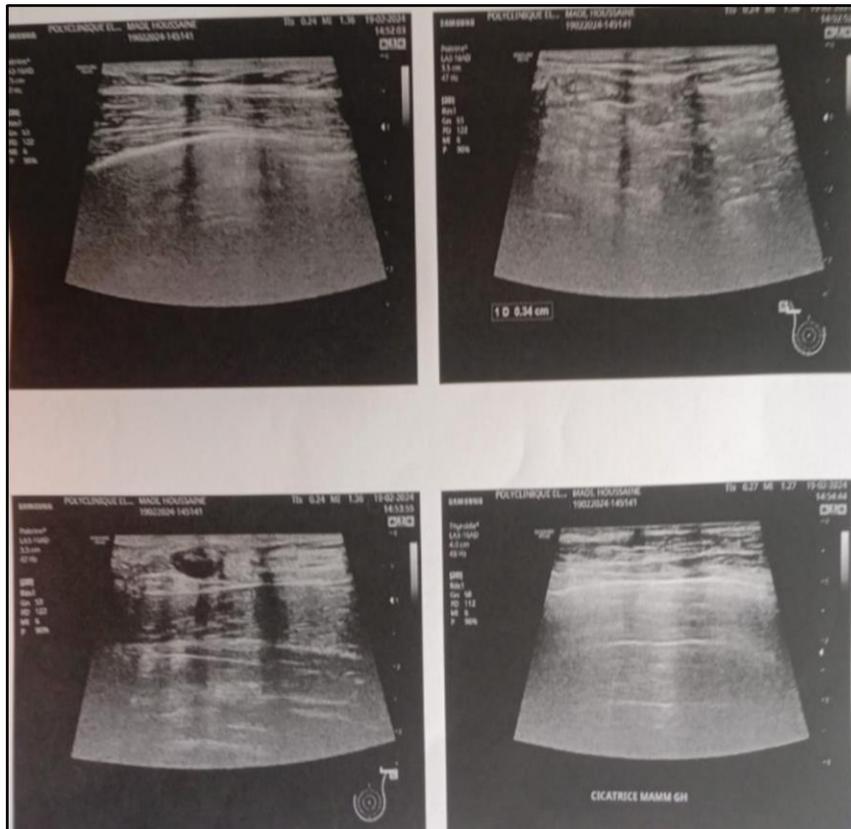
Postoperative mammography and breast ultrasound
